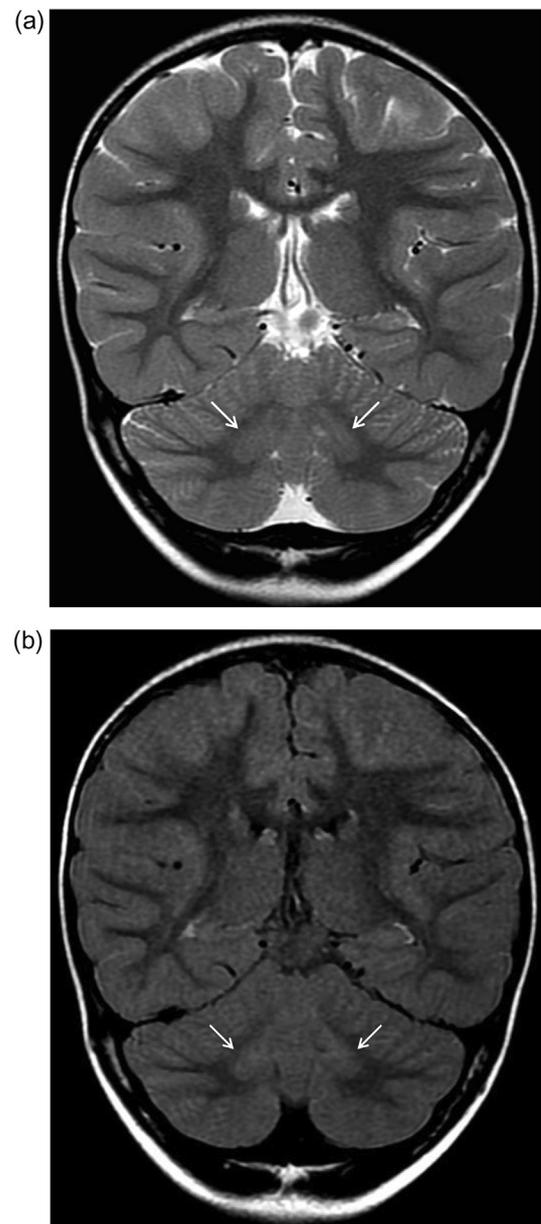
Brain MRI of Patient 2.1: Coronal T2 (A) and FLAIR (B) show bilateral symmetric hyperintensity of the dentate nuclei (arrows).
